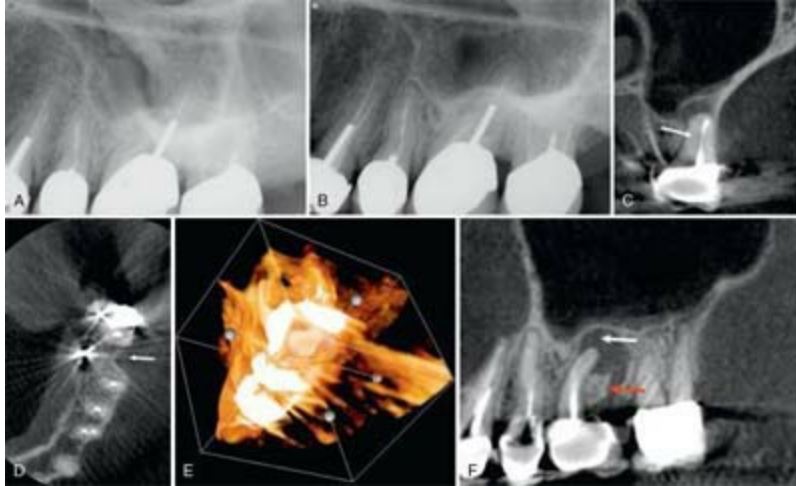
(Case 2, tooth #14): A and B, Periapical radiographs of tooth #14, mesial and distal angles, respectively. C, Coronal view of the MB root demonstrating a missed MB2 canal (*arrow*). D, Axial view showing a previous DB root amputation site (*arrow*) that was not obvious in the periapical radiograph. E, A 3D reconstruction demonstrating a crestal defect. F, Sagittal view demonstrating the crestal defect (*red arrow*) communicating with the periapical lesion (*white arrow*), elevation of the floor of the maxillary sinus but no evidence of sinus perforation.
